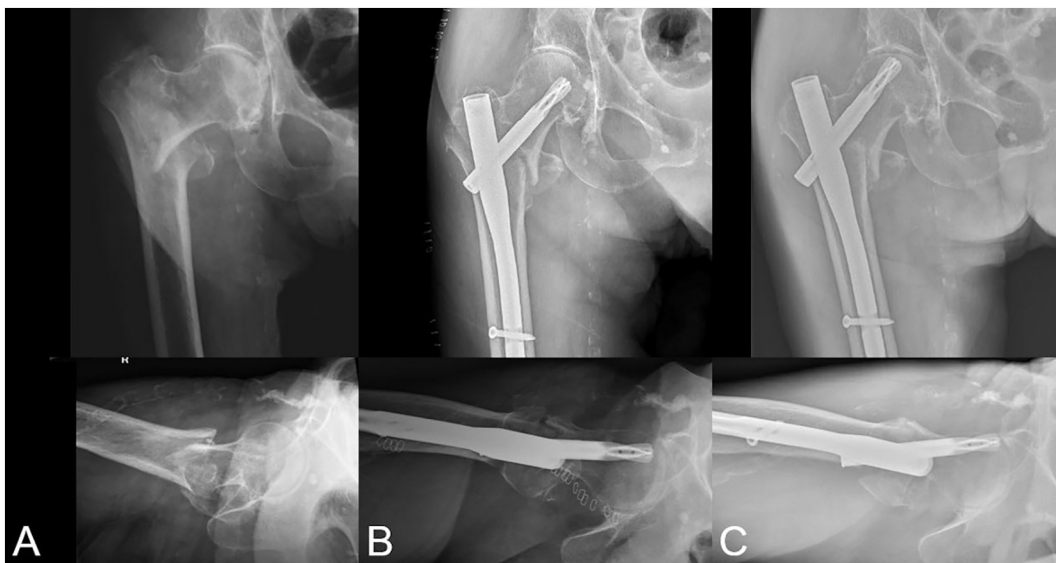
(A) Pre-operative x-rays demonstrating intertrochanteric femoral fracture. (B) Initial postoperative radiograph after closed reduction and internal fixation with PFNA. (C) Radiograph at three-week follow-up showing secondary fracture dislocation and implant migration with blade cut-out.
